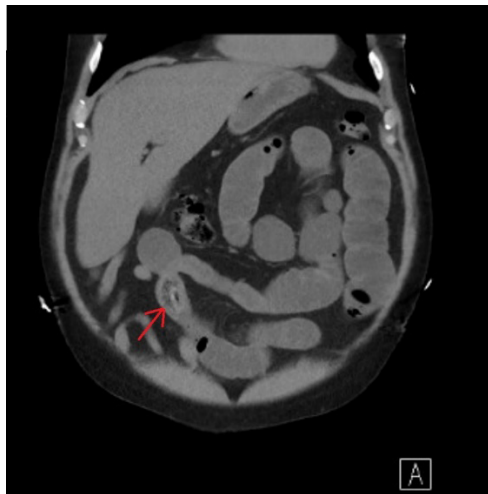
Coronal view of CT abdomen showing intraluminal mass causing mechanical small bowel obstruction
